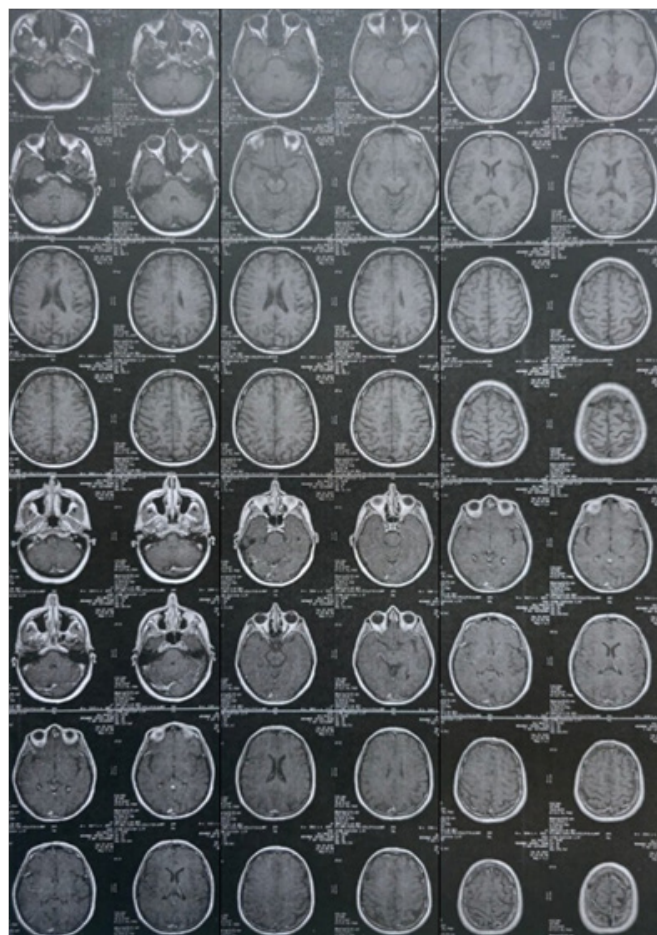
After exosome, Brain MRI without contrast 2 months after injection of exosome was done. Technique was axial T1, T2, PD/W and sagittal T2/W were performed. Findings are as follows: Multiple signal change Lesions in white matter in peri and para ventricles are seen due to demyelinating Lesions. Some of these plaques are located in semi-Centrum ovalis and corona radiata. Large tumefactive plaque in subcortex of left parietal lobe is seen with 18x14mm dimension.
